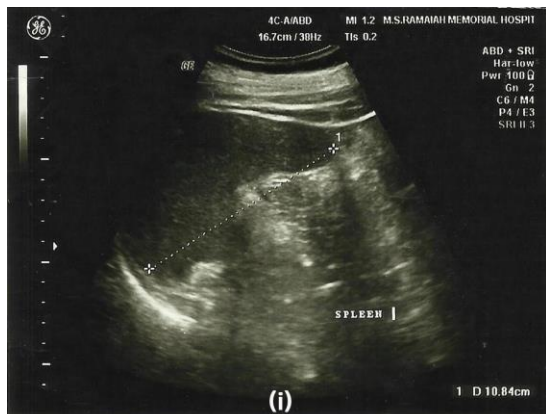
Ultrasound abdomen and pelvis showing multiple small vesicular lesions resembling splenic abscesses (indicated by the arrow)
